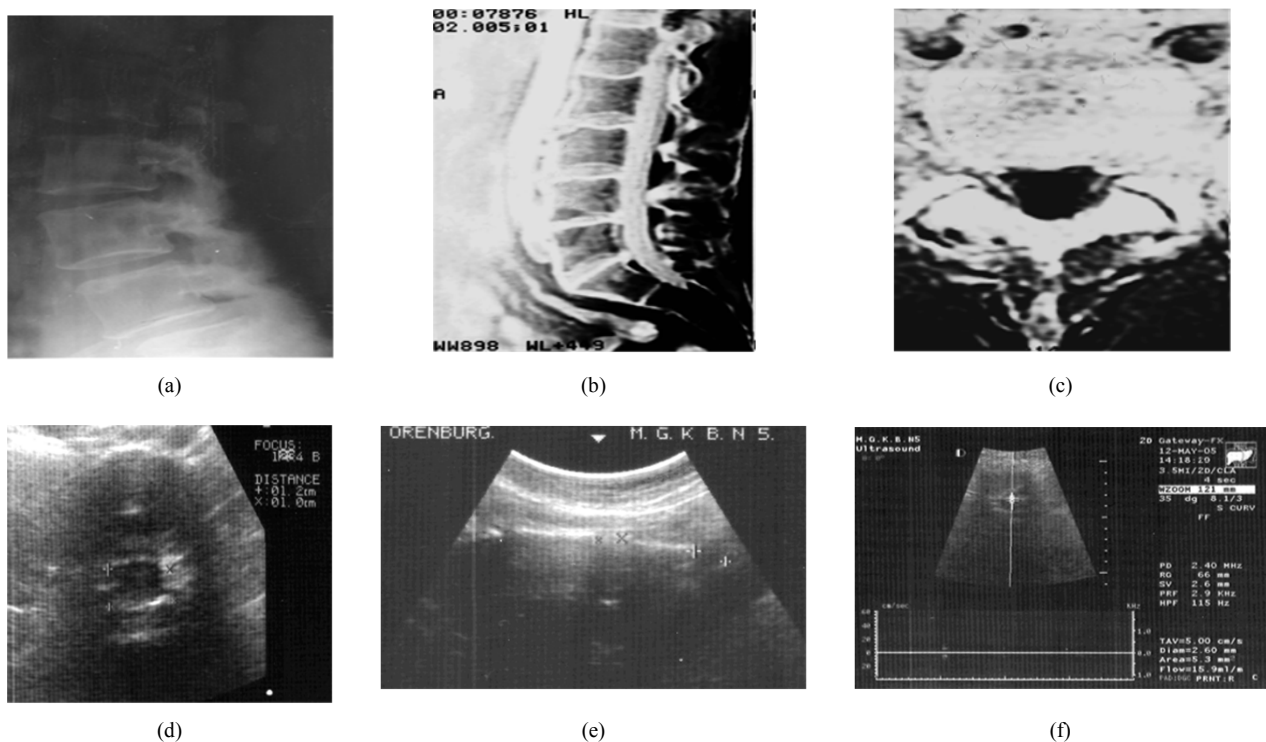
a - The roentgenogram of a lumbar department of a backbone of patient T., 45 years (II stage). The height of disk L4 - L5; b - MRT a lumbar department of a backbone of patient T., 45 years is reduced. The height of disk L4 - L5.; c - Ultrasonic of a lumbar department of a backbone of patient T., 45 years (longitudinal scan) is reduced. The height of disk L4 - L5 is reduced; d - MRT disk L4 - L5. of patient T., 45 years (the pointer designates paramedian to the left on 0,3 sm a hernia); e - Ultrasonic of disk L4 - L5. of patient T., 45 years (a horizontal cut - the pointer designates paramedian to the left on 0,2 sm a hernia); f - A rating of speed of a velocity on epidural vein on not changed disk L3 - L4 Despite lacking positive dynamics as reduction of quantity of patients with hernias of a disk, the number of effectively treated patients in I to group has made 76%, in II group - 82 %. It speaks that, that clinically radicular displays at successful therapy disappear earlier (usually on 3-4-oü to week), than ultrasonic registered reduction of the sizes of hernias. At the average and big sizes of hernias it comes to light only on 6-8 week.
